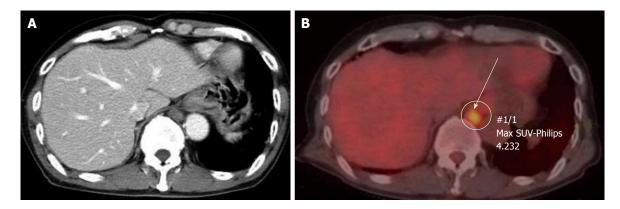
The tumor was 16 mm in size and located in the retrocrural space with suspicion of enlarged lymph nodes. A: Computed tomography (CT) scan showing a 16-mm tumor in the retrocrural space of the lower mediastinum; B: Positron emission tomography-CT did not reveal any other abnormal accumulation. The mediastinal mass had 4.232 of the sum of the maximum standard uptake values. SUV: Standardized uptake value.
